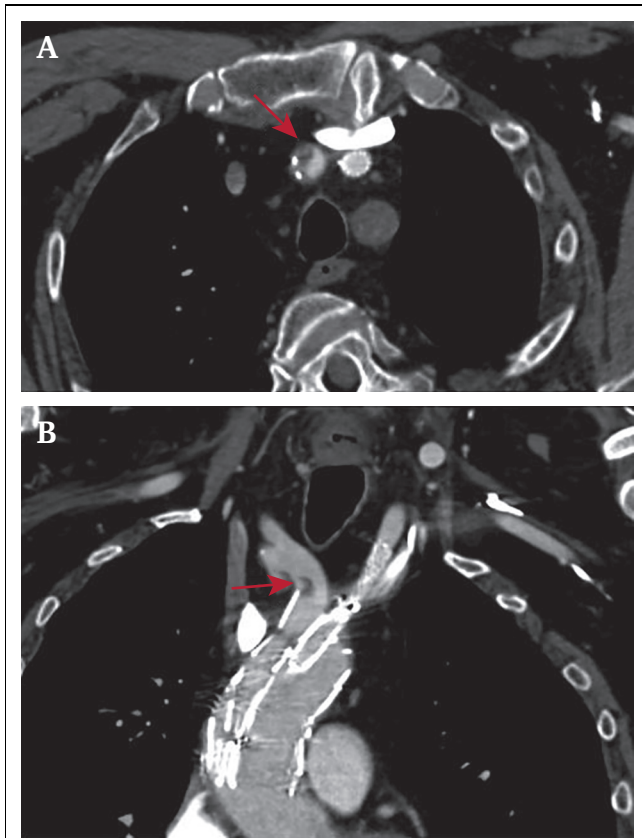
(A) Transverse and (B) coronal computed tomography angiography views of an arch branched device with branches to the innominate and left common carotid artery, showing thrombus in the innominate artery branch (red arrows).
